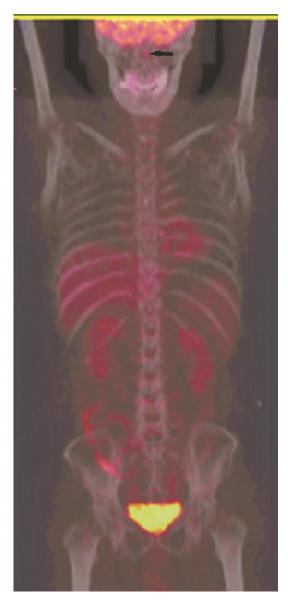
18FDG PET/CT scanning revealed increased uptake in the left nasal septum.
